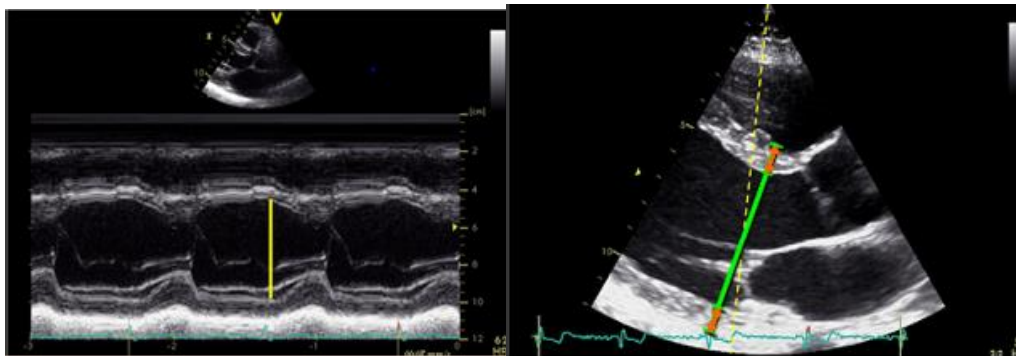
Right side: Linear measurements in the parasternal long axis view. Left side: The same view using M-Mode modality.
